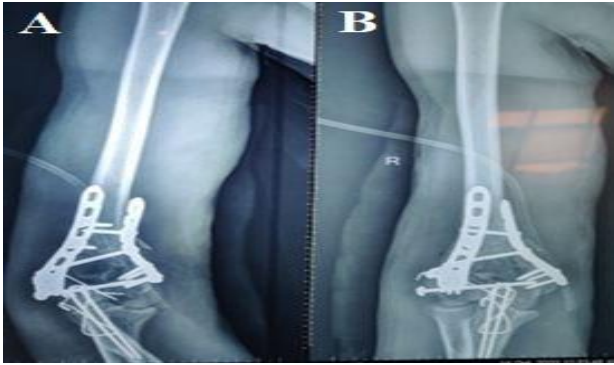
(A and B) Post-operative radiograph showing fixation of distal humerus fracture with bicolumnar plating.
